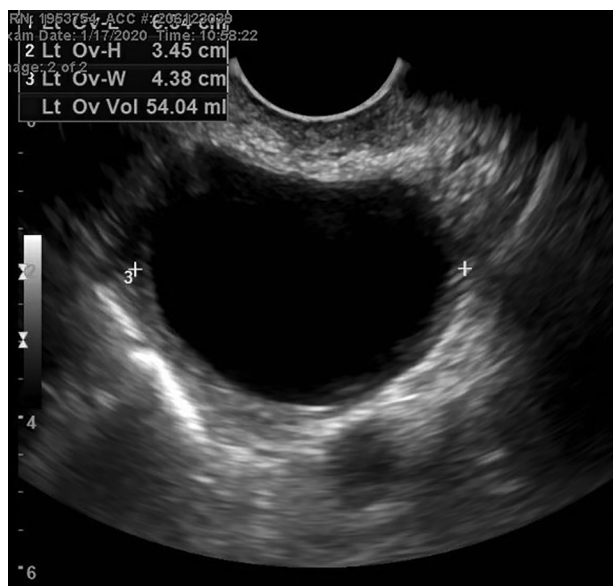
Pelvic sonogram reveals a 6.5 cm hypoechoic to anechoic cystic lesion in the left adnexa.
